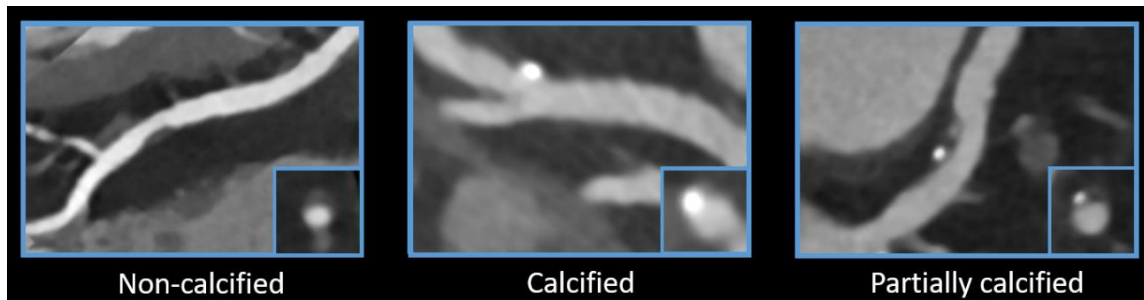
Qualitative plaque analysis on conventional CT reading (*own material*).
